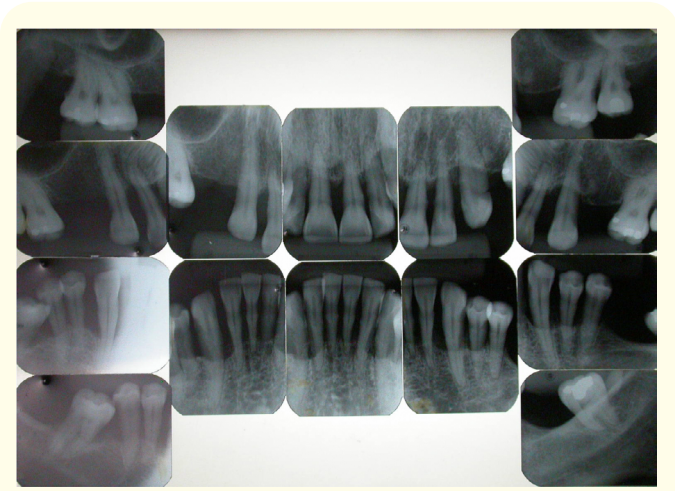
Periapical radiographs: details of bone loss and radiopaque images of dental calculus.
